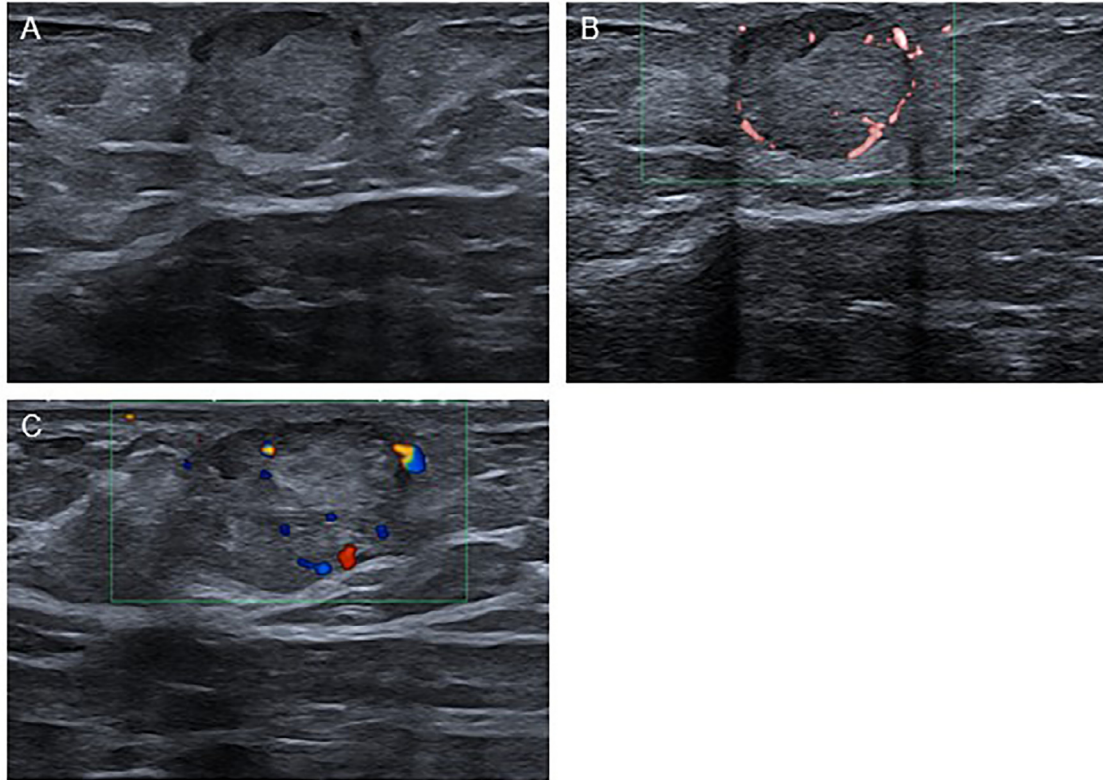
Initial ultrasound of right axillary lesion. (A) A well-circumscribed heterogeneous mass measuring 10 × 13 mm. Peripheral (B), and internal (C) vascularity on power Doppler and color Doppler respectively.
